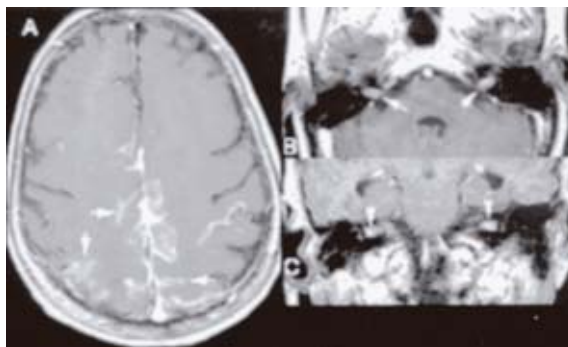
Enhanced (a, b) axial and (c) coronal (C) T1-W MR images show enhancement in the convexity sulci (arrows in a) and the interhemispheric fissure, and in both the internal auditory canals (arrows in b & c).
